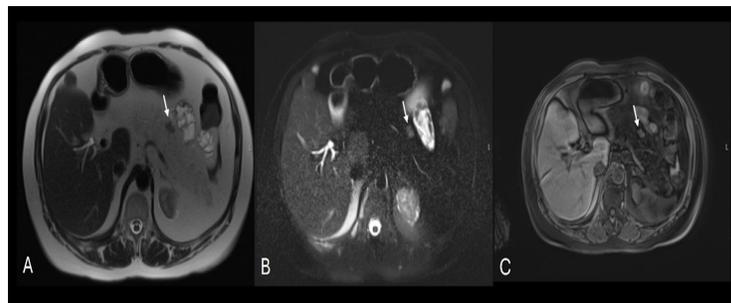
Magnetic resonance imaging (MRI) of the abdomen obtained three years before Figure 1. Axial (A) T2-weighted, (B) T2-weighted fat saturated, and (C) T1-weighted fat saturated pre-contrast images. (A) Macroscopic fat signal throughout the pancreas. (B, C) Diffusely hypointense pancreatic signal on fat saturated sequences. Small focus of tissue within the anterior pancreatic body (white arrow) with signal characteristics of normal parenchyma indicating an area of fatty sparing.
